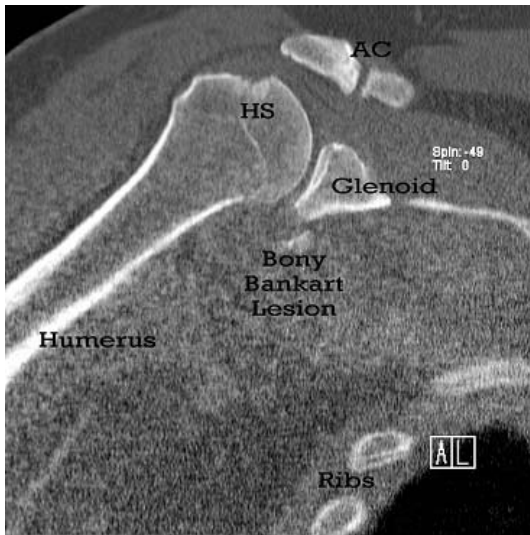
Reconstructed CT of the right shoulder – axillary view (HS = Hill-Sachs lesion)
